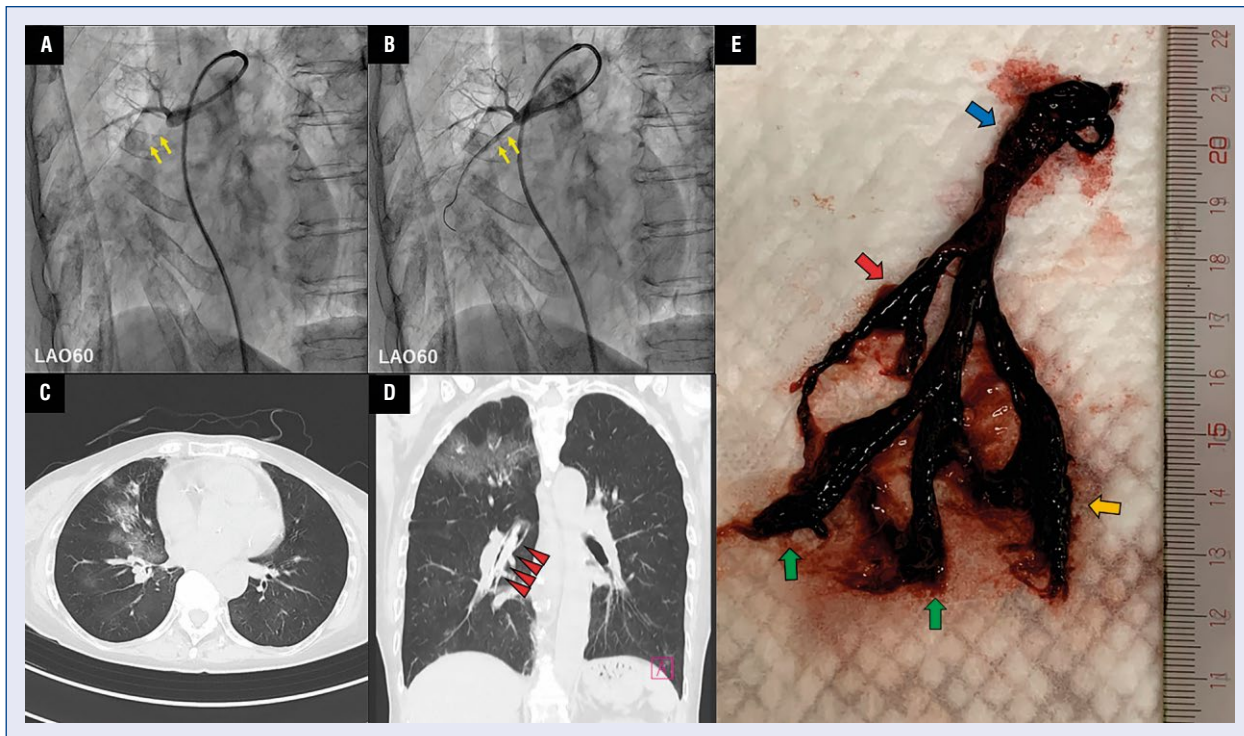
The process of balloon pulmonary angioplasty, computed tomography performed after balloon pulmonary angioplasty, and the expectorated blood clot; A. Pulmonary angiography showing chronic total occlusion in right A5 segment (yellow arrows); B. Revascularization of right A5 segment after balloon pulmonary angioplasty (yellow arrows); C. Computed tomography showing an infiltrative shadow in the right middle medial lobe; D. Computed tomography showing an infiltrative shadow in the right superior apical lobe and a space occupying lesion detected in inferior lobar bronchus (red arrowheads); E. Blood clot shaped like a bronchial tree, consisting of inferior lobar bronchus (blue arrow), anterior basal branch (red arrow), lateral basal branch (green arrows), and posterior basal branch (orange arrow).
